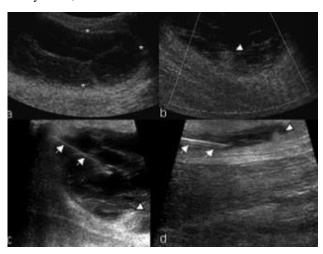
Ultrasound image of the right femur in a patient after a bicycle accident shows a large cavity with separations and fluid in deep subcutaneous tissues (stars) that corresponds to Morel-Lavallée lesion (a). Doppler study showed the absence of internal blood flow (b). A spinal needle 20-caliber catheter was introduced into the cavity under the US control, 85 cm³ of serous hemorrhagic fluid was removed (c). Captured portions of the fat tissue look like bright hyperechogenic nodes in the injury area (arrows) (c and d). Presented by Chokshi F.H. et al., 2010, pages 252-263 [29]
